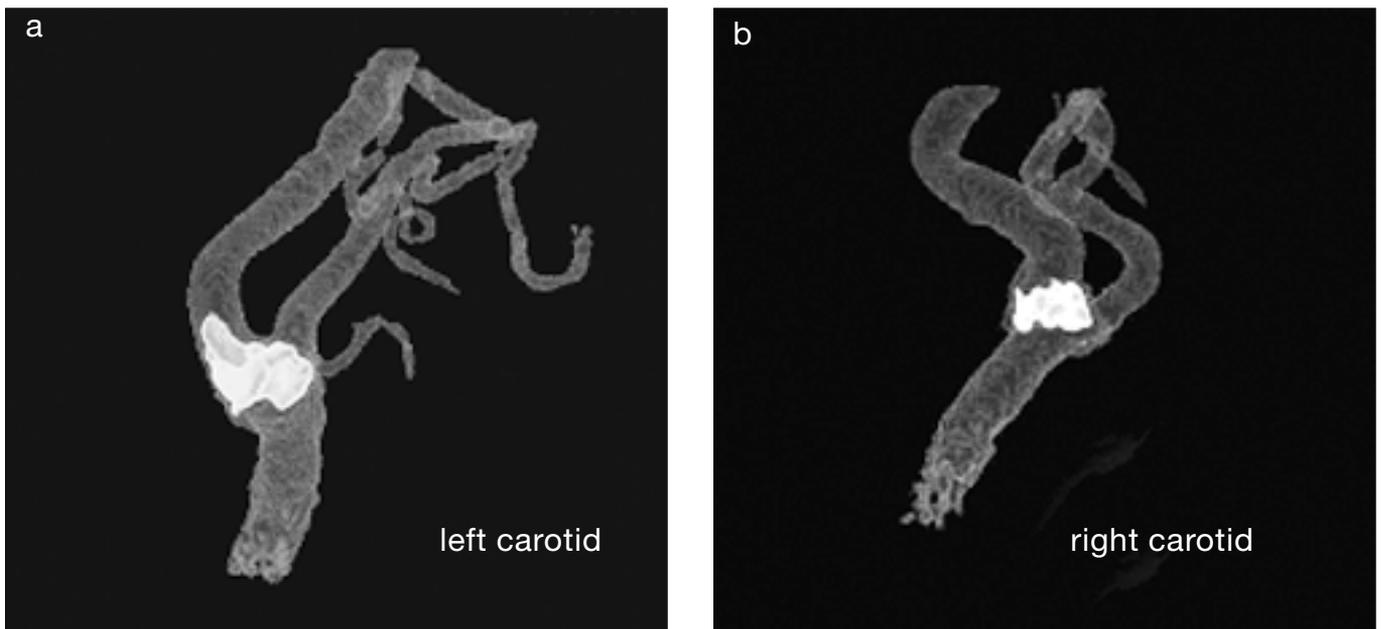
Vascular calcification in CKD. A representative hemodialysis patient with remarkable bilateral carotid artery calcifications. Doppler analysis revealed a 60% stenosis in the left carotid artery (a) and a 70% stenosis in the contralateral artery (b). The patient had a sudden death 5 months after this CT scan was performed.
